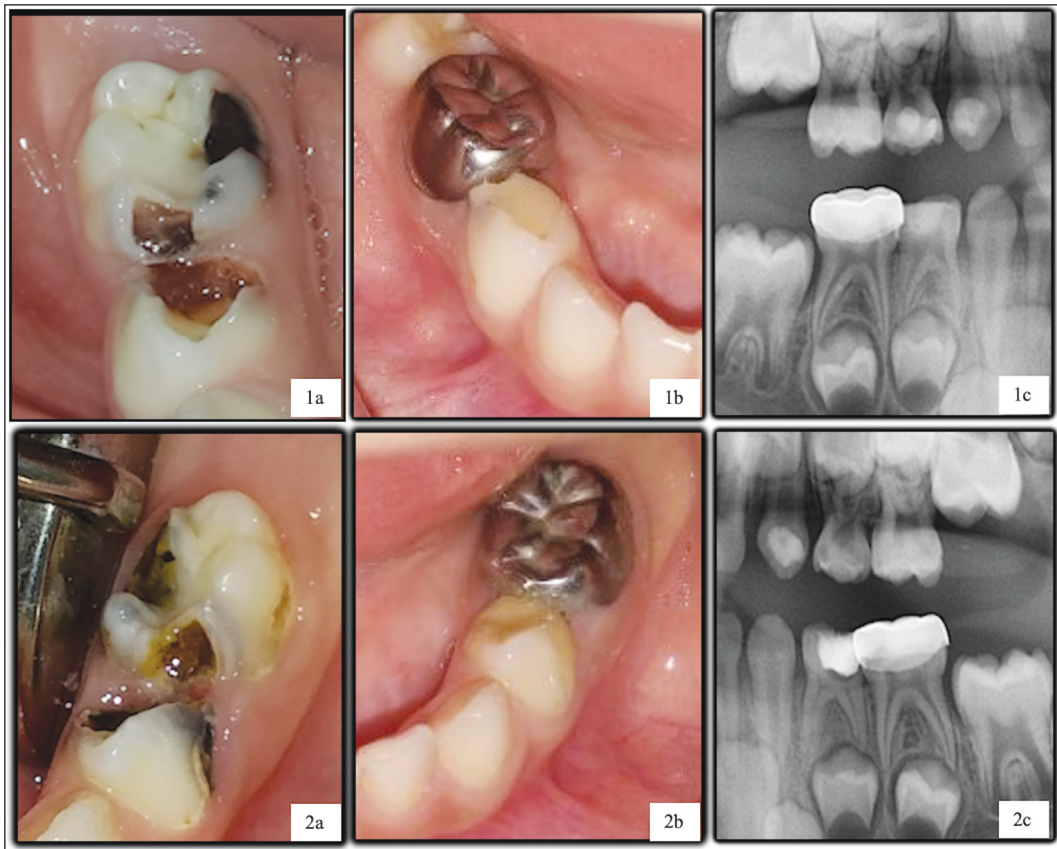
Clinical and radiographic images of the Hall Technique
